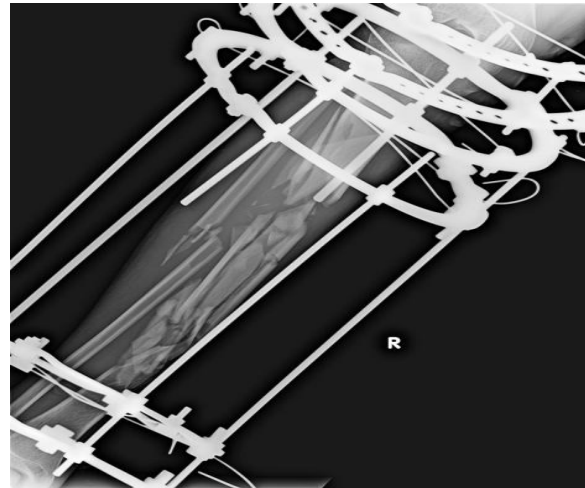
comminuted and segmental tibia # pre and post operative x-rays
